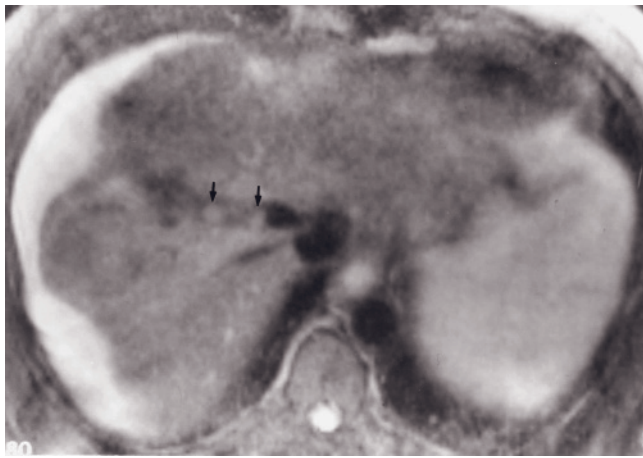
(Continued) Coronal T2-weighted SS-ETSE (*k*), SGE (*l*), and immediate (*m*) and 90-s fat-suppressed (*n*) postgadolinium SGE images in a third patient with a diffuse HCC and tumor thrombus of the right portal vein. T2-weighted fat-suppressed SS-ETSE (*o*), SGE (*p*) and immediate (*q*) and 90s postcontrast fat-suppressed 3D-gradient echo images at 3T demonstrate poorly defined diffuse HCC in the right lobe. Note intense early enhancement of the tumor thrombus (*q*).
